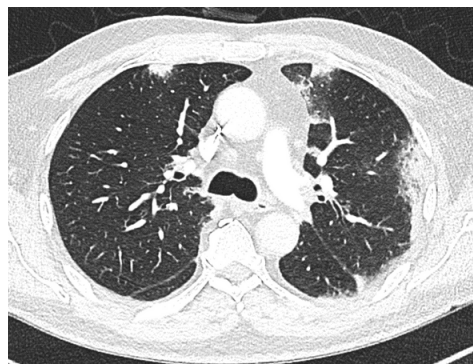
Computed tomography scan with multifocal sub-pleural infiltrates
